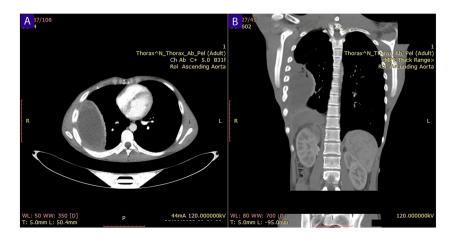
Chest CT images. (A) Axial section and (B) Coronal section reveal a right-sided pleural effusion with multiple thick septations.
